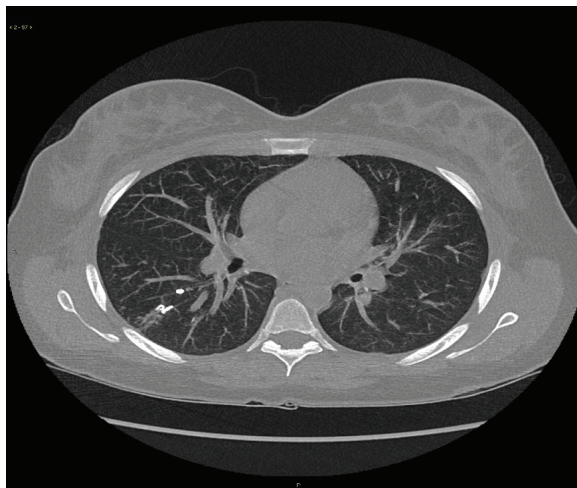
Pre-pregnancy chest CT showed no evidence of re-perfusion of the previously embolized right lower lobe AVM or new pulmonary AVMs.
